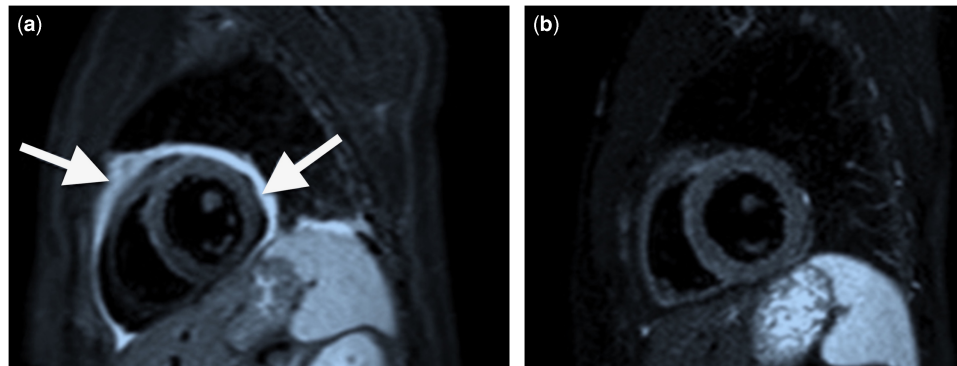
(a) Cardiac MRI (short-axis view) performed on March 2015 under treatment with prednisone 1 mg/kg/day. The late gadolinium sequence showed a diffuse enhancement above the whole pericardium (white arrows), as a sign of active pericardial inflammation. (b) Cardiac MRI (short-axis view) performed on July 2015, 3 months after the initiation of anakinra 1 mg/kg/day. The late gadolinium sequence showed no enhancement; therefore the pericardial inflammation was then controlled.
